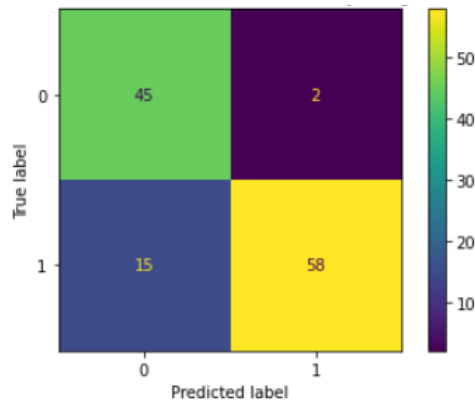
Confusion Matrix CNN+SVM:- X-ray Image
